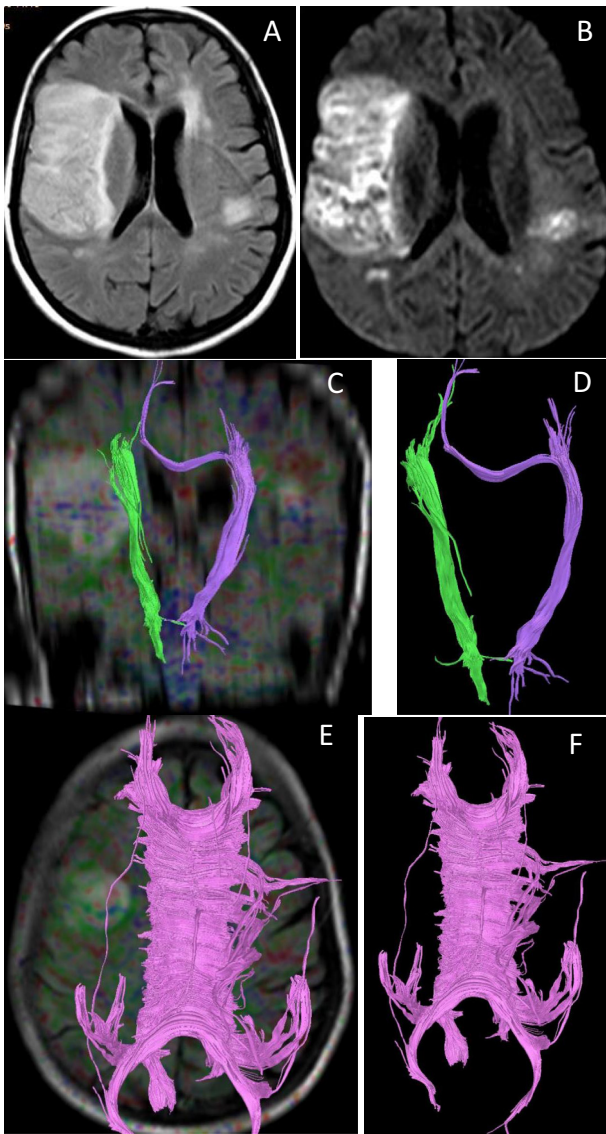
(A) Axial FLAIR WIs in a female patient 60 years old presented with left hemiplegia show cortical and subcortical area of high signal at the right parietal region measuring about 8.5×4 cm in diameters. (B) Axial diffusion WIs (b1000) show restricted diffusion of the lesion. Note the smaller left parietal acute infarction. (C) Coronal FA color coded map overlaid over coronal FLAIR image with fiber tractography of the CST. (D) 3D fiber tractography of the CST. The right CST (green) appears displaced medially by the lesion yet it appears preserved. (E) Axial FA color coded map overlaid over axial FLAIR image with fiber tractography of the CC. (F) 3D fiber tractography of the CC. The right tapetum and right fibers of the body of the corpus callosum appear disrupted.
